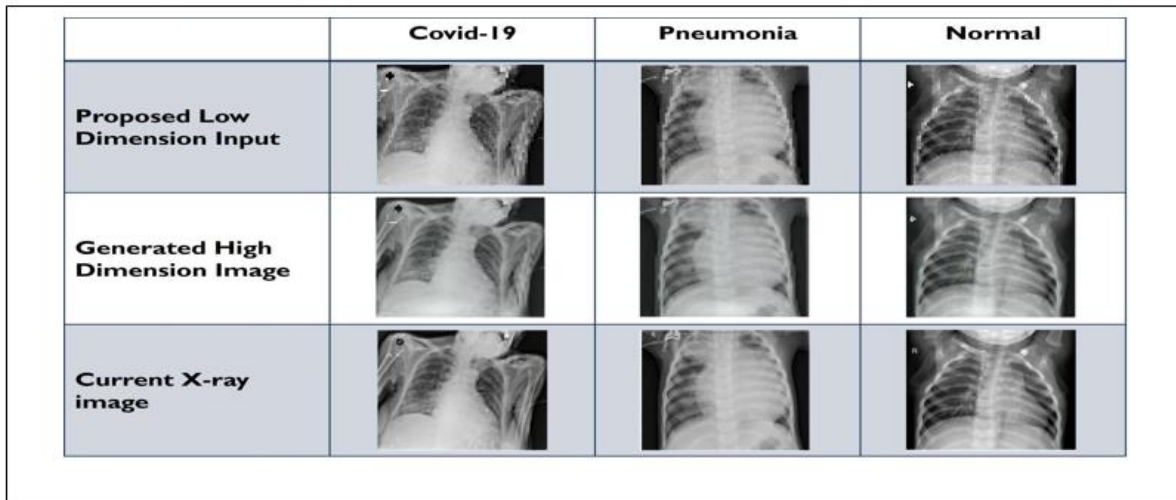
Proposed Low Dimension X-ray images, Generated High Dimension X-ray images from the low dimension input using SRGAN and Current images in the dataset
